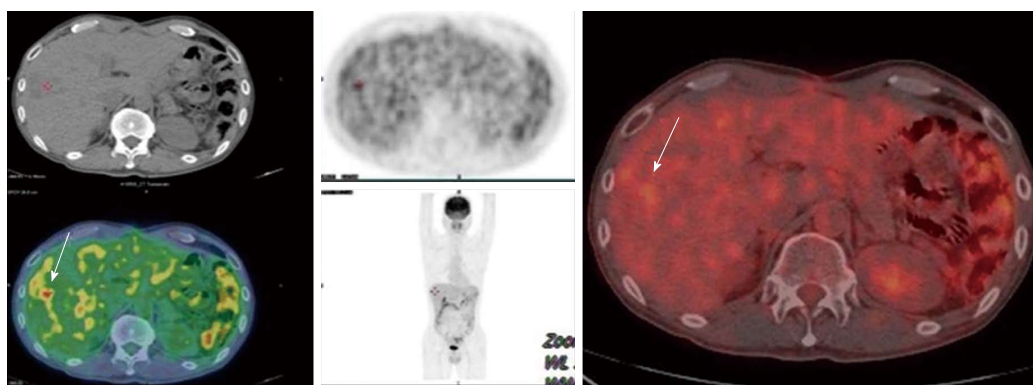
This arterial enhances mass like lesion had a hypermetabolism in positron emission tomography computed tomography.
